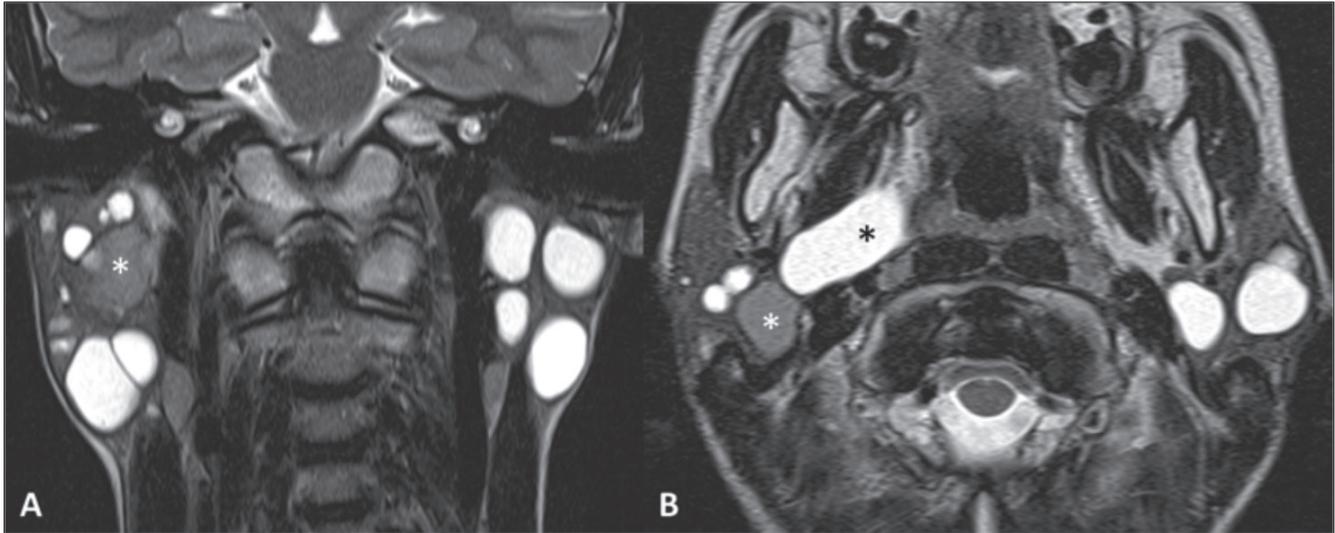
Bilateral benign parotid lymphoepithelial cysts in a HIV-positive patient. MR TSE T2-weighted sequences on the coronal (A) and axial (B) planes. Multiple cystic lesions in the parotid glands, among which a high-protein content cyst (white asterisk) and a cyst extending in the right parapharyngeal space reaching the lateral wall of oropharynx.
